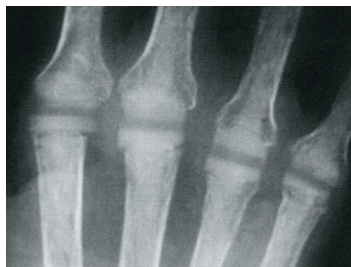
X-ray of MP joint arthritis. The joint on the right has no space between the bones when compared to the joint on the left because of cartilage loss
